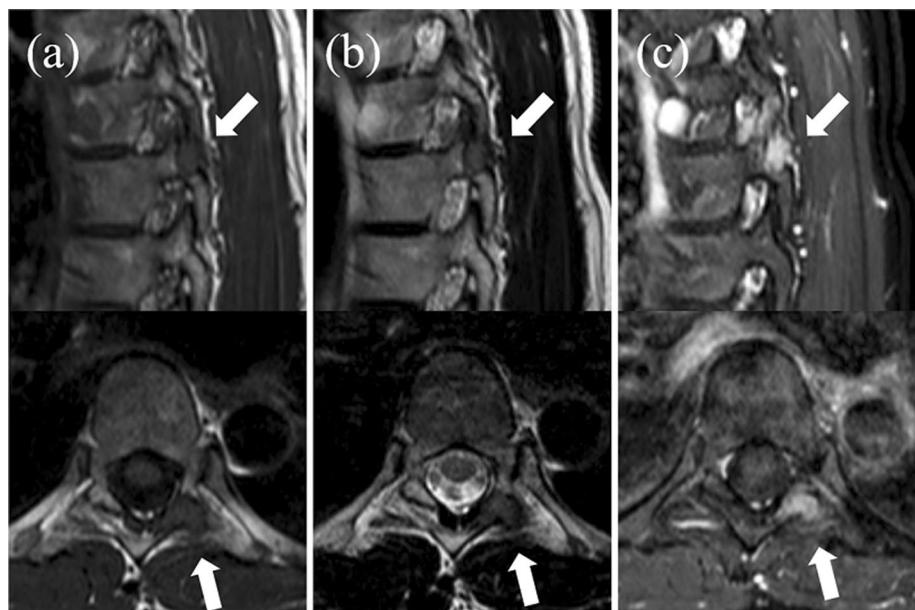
Preoperative magnetic resonance imaging of the thoracic spine. T1- and T2-weighted images (a, b, respectively) showing low signals. Tumor enhancement was observed with gadolinium contrast (c). The white arrows indicate the tumor
